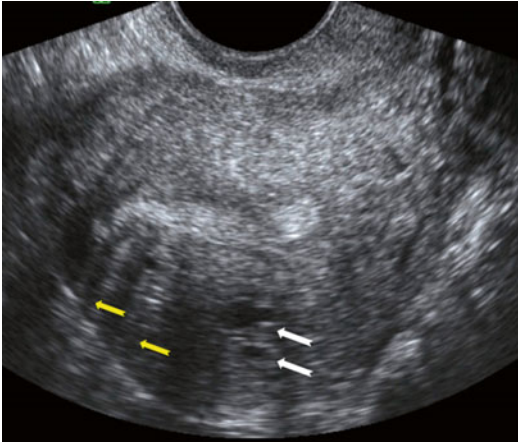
Ultrasound image of a uterus with adenomyosis. Note the round cystic anechoic areas (*white arrows*) in the myometrium below the endometrium and hypoechoic linear striation (*yellow arrows*)
